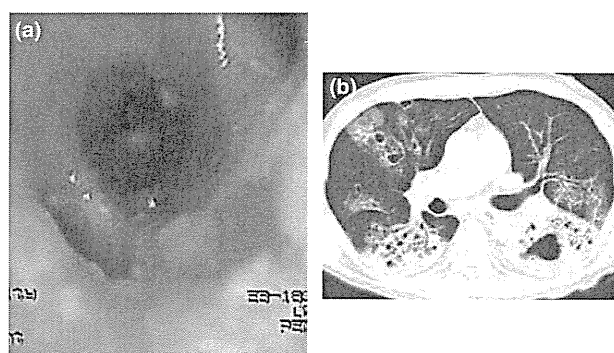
Imaging analysis for the respiratory involvement. (a) Bronchoscopy showed severe involvement of bronchial epithelium. (b) Chest computed tomography showed obvious consolidation, ground-glass appearance with bronchiectasis and cavitation including abscess predominately in the dorsal area.
